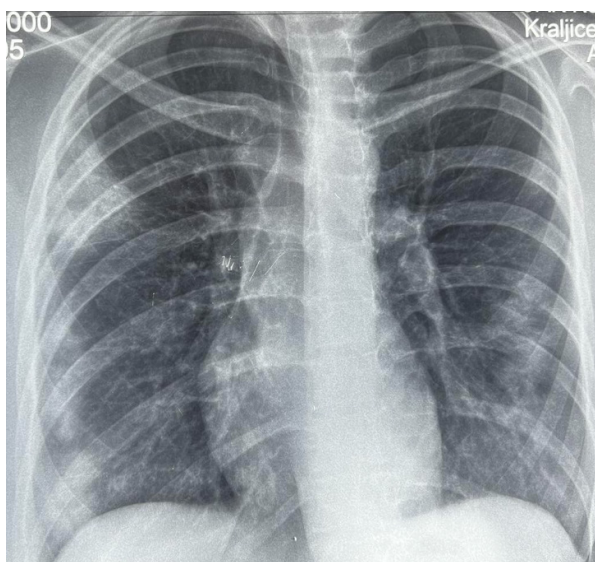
The first X-ray of the lungs
